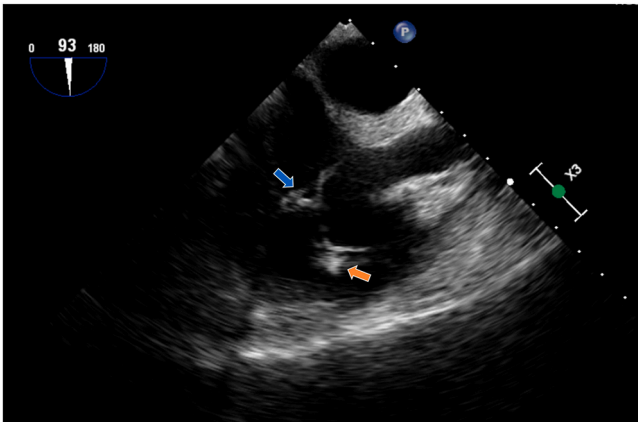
Vegetation on tricuspid valve and vegetation on right ventricular pacemaker lead on transthoracic echocardiogram.
